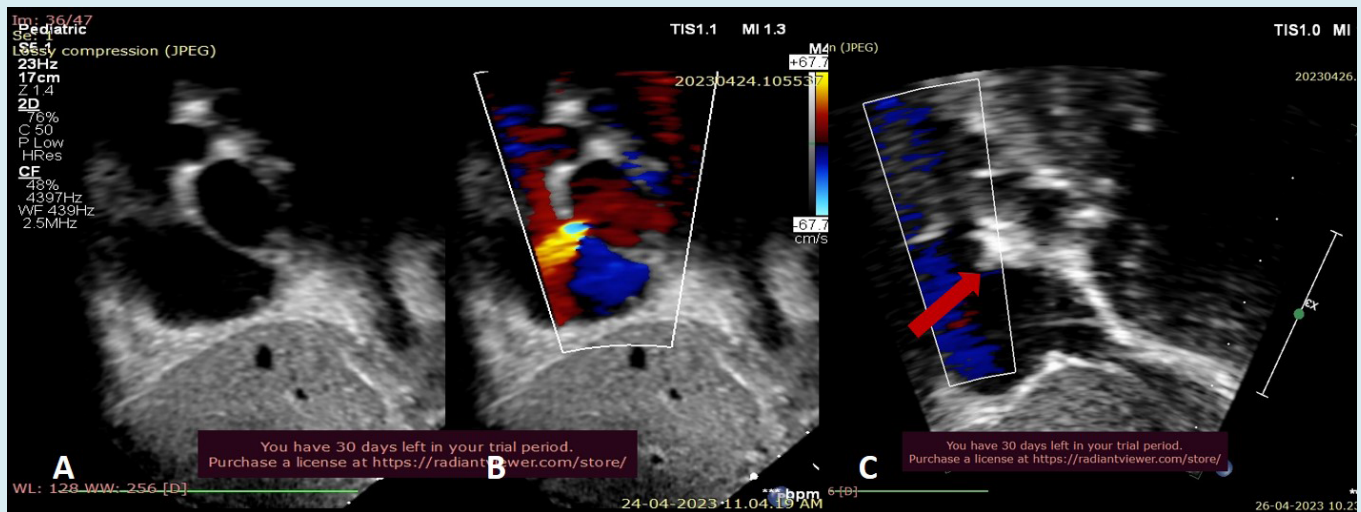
(A): 2D Echocardiogram done in subcoastal bi-caval view with colour interrogation; (B): showing small Atrial Septal defect shunting from left atrium to right atrium; (C): Subcoastal view in the same child after device closure showing device in situ and no residual shunt (red arrow).
